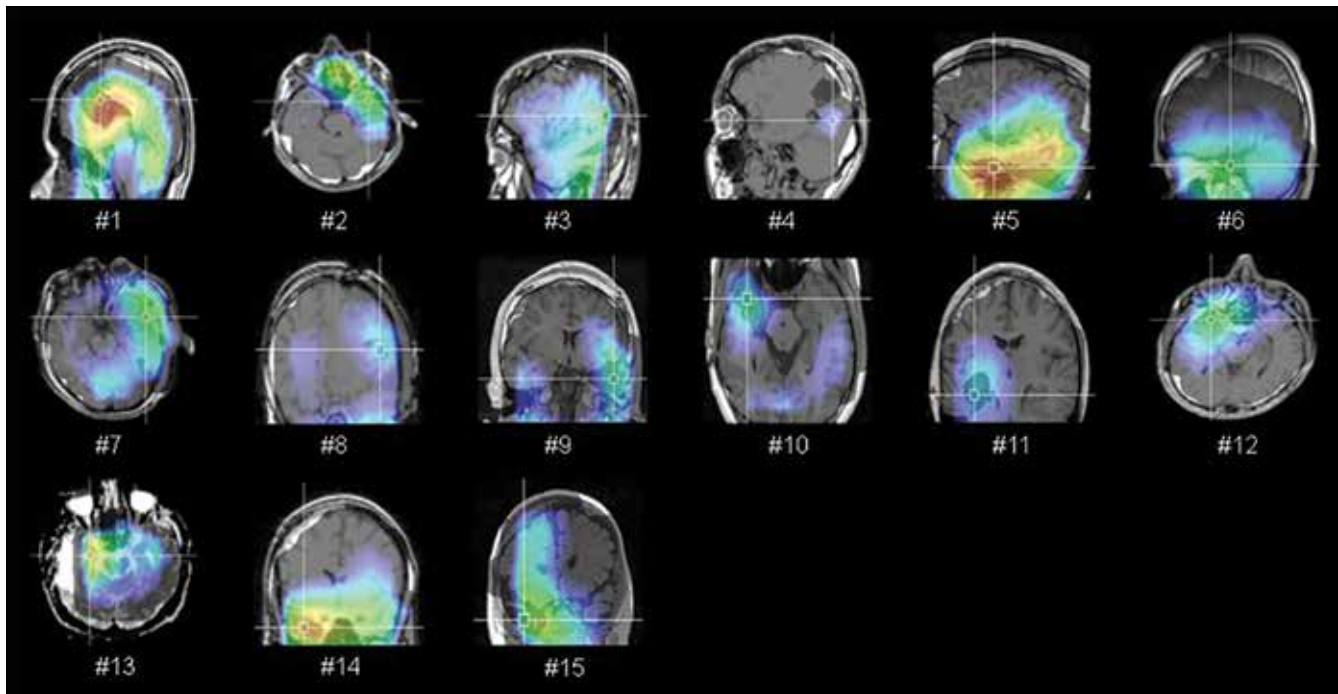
The superposed images of LORETA source localization maps obtained by analyzing EEG ictal activity and postoperative MRI: Individual head model (dark gray color), including brain, skull and scalp was created using postoperative MRI scans for each patient. Electrode positions were localized, EEG analysis was performed, and electrodes were registered with individual head model. Finally, LORETA method was conducted to obtain ESL map and the highest activation area marked with crosshair. The ESL area we have found using LORETA method overlapped with brain resected area (black) except for the patients #4 and #13
